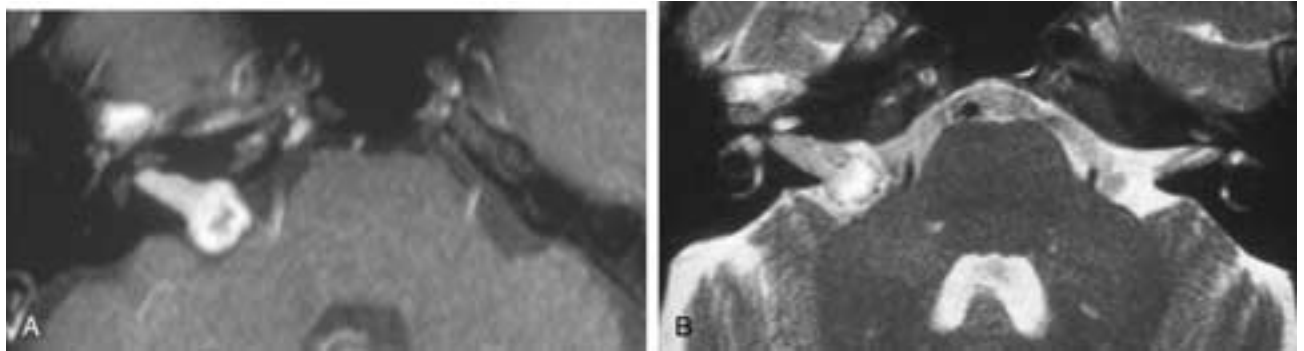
IAC facial schwannoma. A and B, postgadolinium T1-weighted and T2-weighted images. This patient presented with progressive sensorineural hearing loss and later developed facial palsy. The enhancing intracanalicular tumor is indistinguishable from an acoustic schwannoma. Note also the extension of the tumor to the geniculate ganglion.
